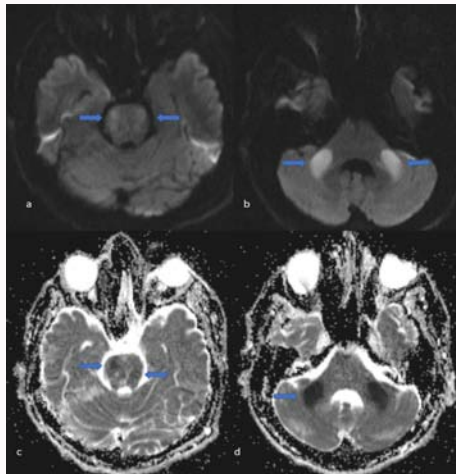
Diffusion MRI showed bilateral Pontine (a,c) and middle cerebellar peduncle infarcts (b,d) as showed by arrows.
